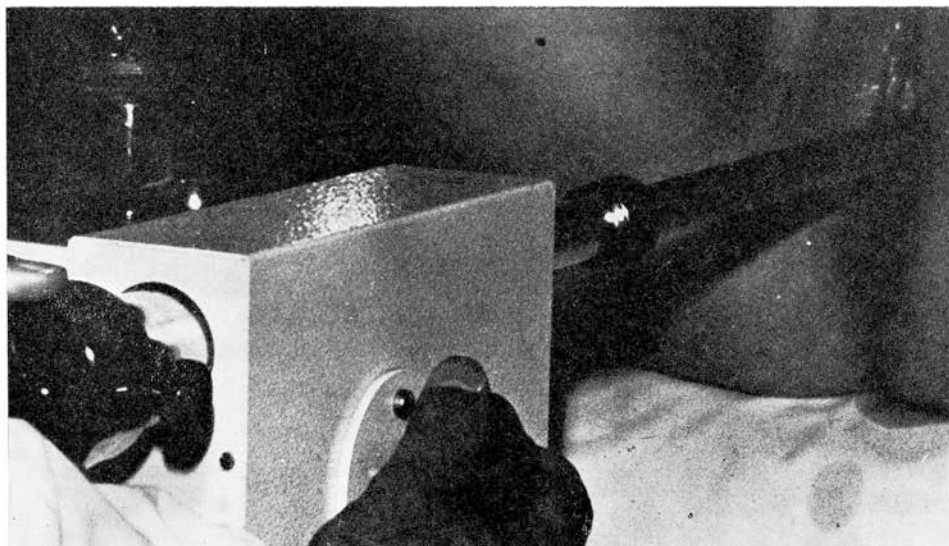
The endovaginal ultrasonic probe is introduced into the vagina in such a way that its end is in the anterior fornix.
